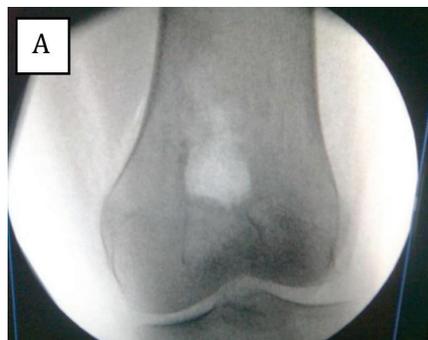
Radiographic preoperative aspect (A) and final aspect after excision (B) of the periosteal osteoid osteoma of the distal femur.
